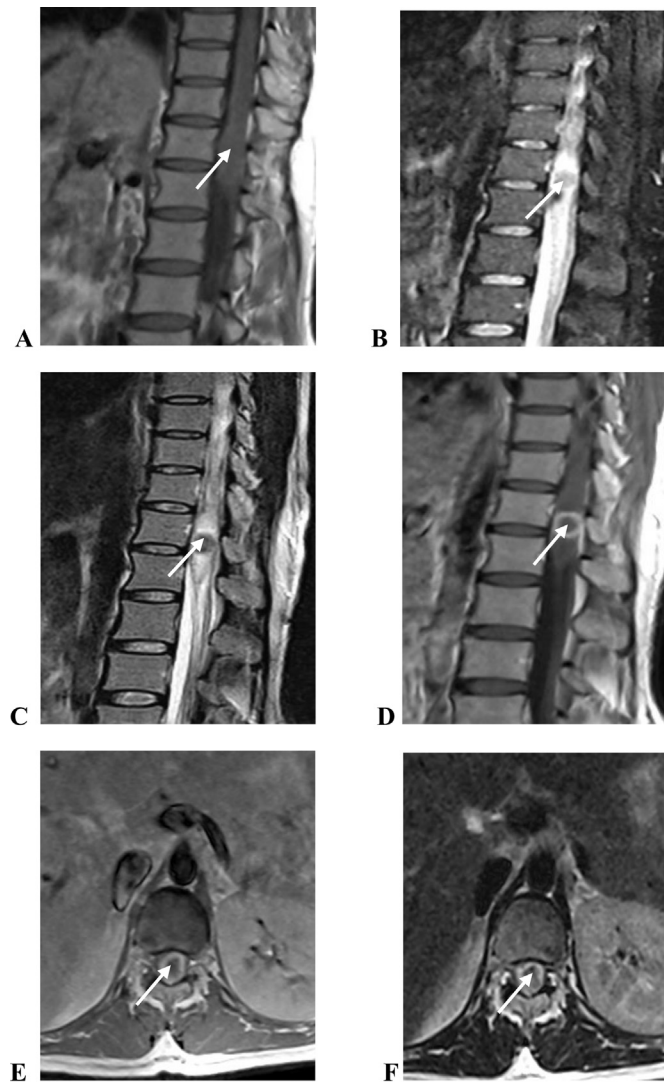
Case 2. Thirty-year-old male with caseous stage spinal TB. The multiplanar, gadolinium-enhanced MRI shows an oval, well-defined and intradural-intramedullary lesion measuring 14 × 12 mm located at the T12 vertebral level within the spinal cord. On T1-weighted imaging, the lesion is isointense (arrow, A). On STIR and T2-weighted imaging, the lesion appears hypointense, surrounded by a hyperintense rim (arrows, B, C, D). On postgadolinium imaging, the lesion exhibits a peripheral smooth ring enhancement with central hypointensity, demonstrating the characteristic “target sign” appearance showing caseous stage spinal TB (arrows, E, F).
